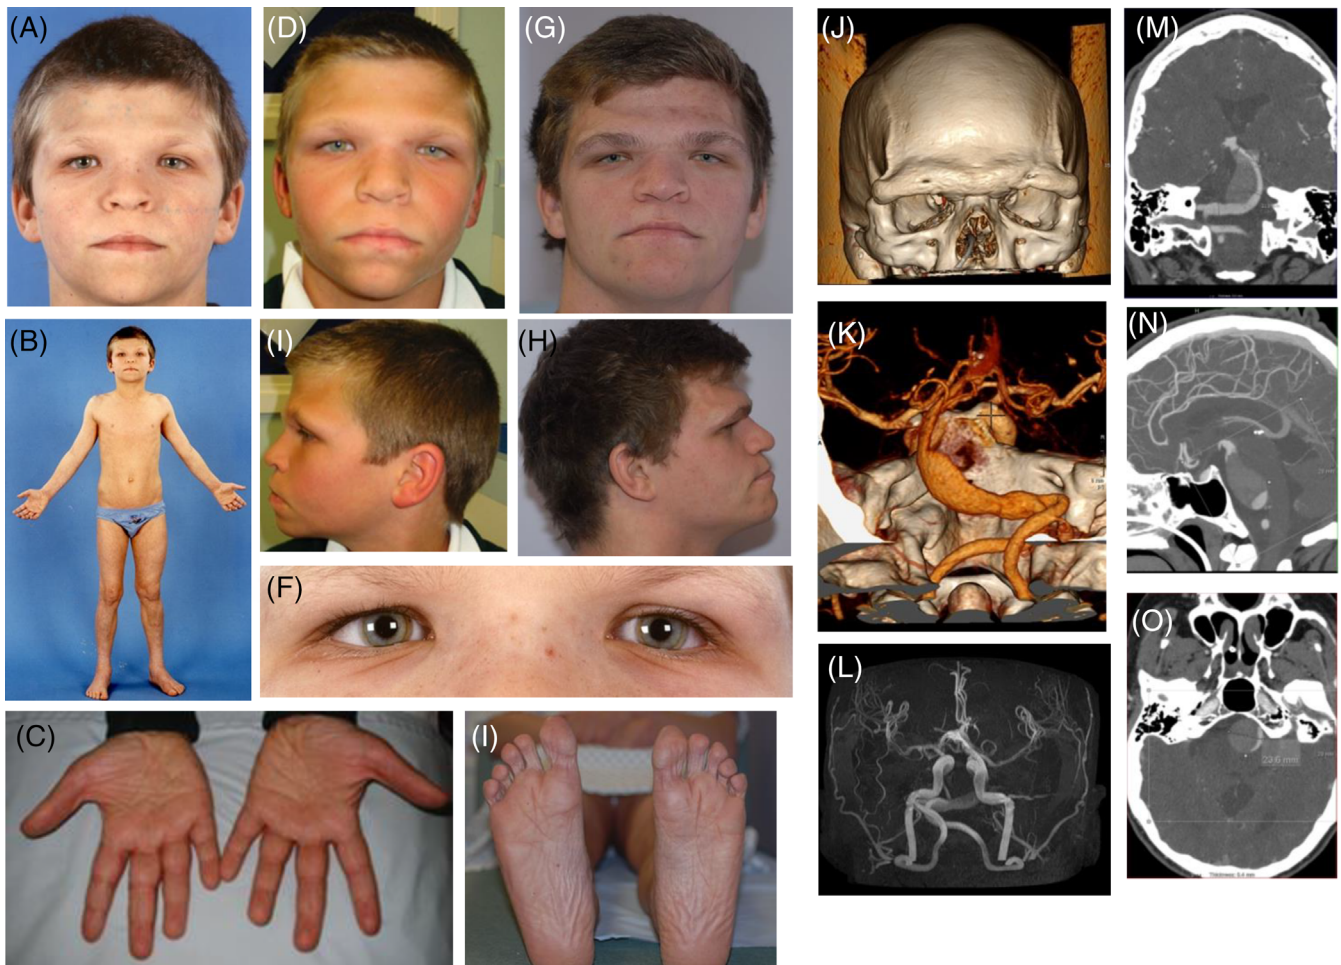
Clinical features and imaging of patient 3. Facial features: prominent supraorbital ridges, broad nose and broad nasal bridge age 9, A, age 11, D,I, and age 20, G,H. Yellow ring around the iris, F. Reduced subcutaneous fat, B. Large hands with broad digits, C, and thin hyperelastic skin with wrinkled palms and soles, C,I. J,K: Intracranial CT angiogram showing prominent frontal bone and thrombosis of a large fusiform aneurysm of the basilar artery, the majority of which is thrombosed. L-O, MRA head showing large fusiform aneurysm of the basilar artery indenting the brain stem and including an area of thrombosis, multiple foci of signal change in the supratentorial white matter in keeping with chronic small vessel ischaemia, and multiple areas of presumed dural ectasia with thinning of the skull vault and skull base [Colour figure can be viewed at wileyonlinelibrary.com]
